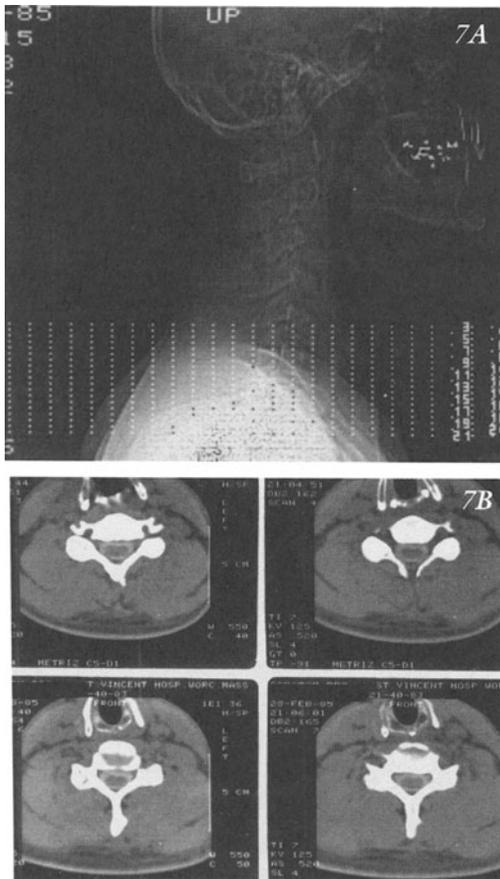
CT Computerized Axial Tomography (CT) after metrizamide myelography: normal spinal cord. A) Reference film for level of cross sections in this patient. B) Scans 3, 4, 6, 7- sections through C5-C6 Levels.
